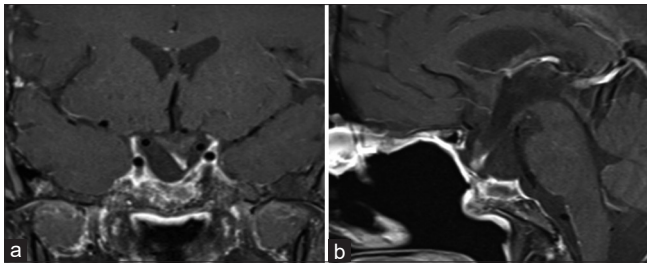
Postoperative pituitary magnetic resonance imaging (April 2019): Coronal (a) and sagittal (b) images show postoperative changes seen at the sellar and suprasellar region with persistent displacement of the optic chiasm inferiorly and the pituitary stalk toward the left side with no definite residual or recurrent masses at the surgical bed
